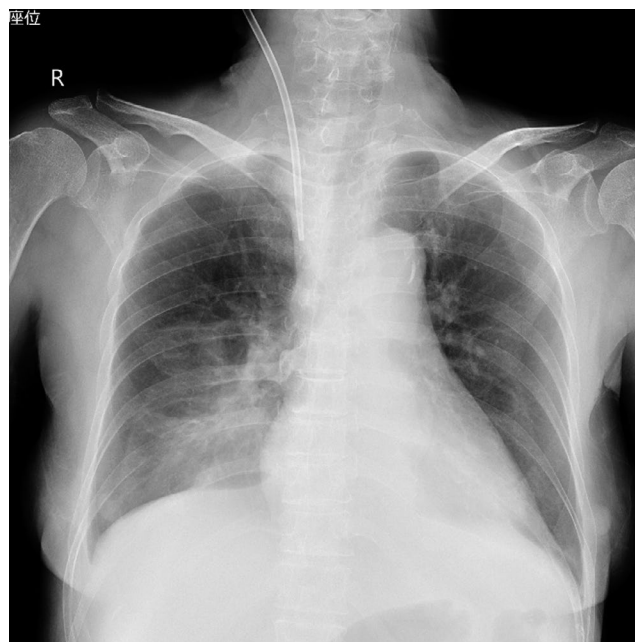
Chest X-ray after the insertion of a double-lumen catheter to check the catheter location. This figure shows the catheter positioned appropriately
